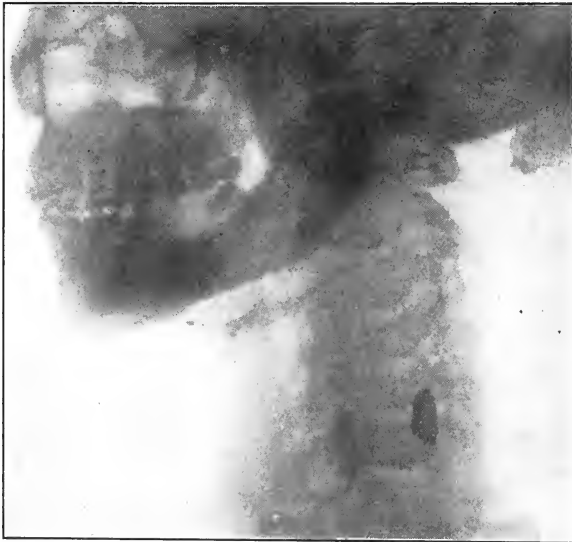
X-RAY PICTURE OF BULLET WOUND OF THE ESOPHAGUS DESCRIBED IN THE TEXT. (Author's collection.)
